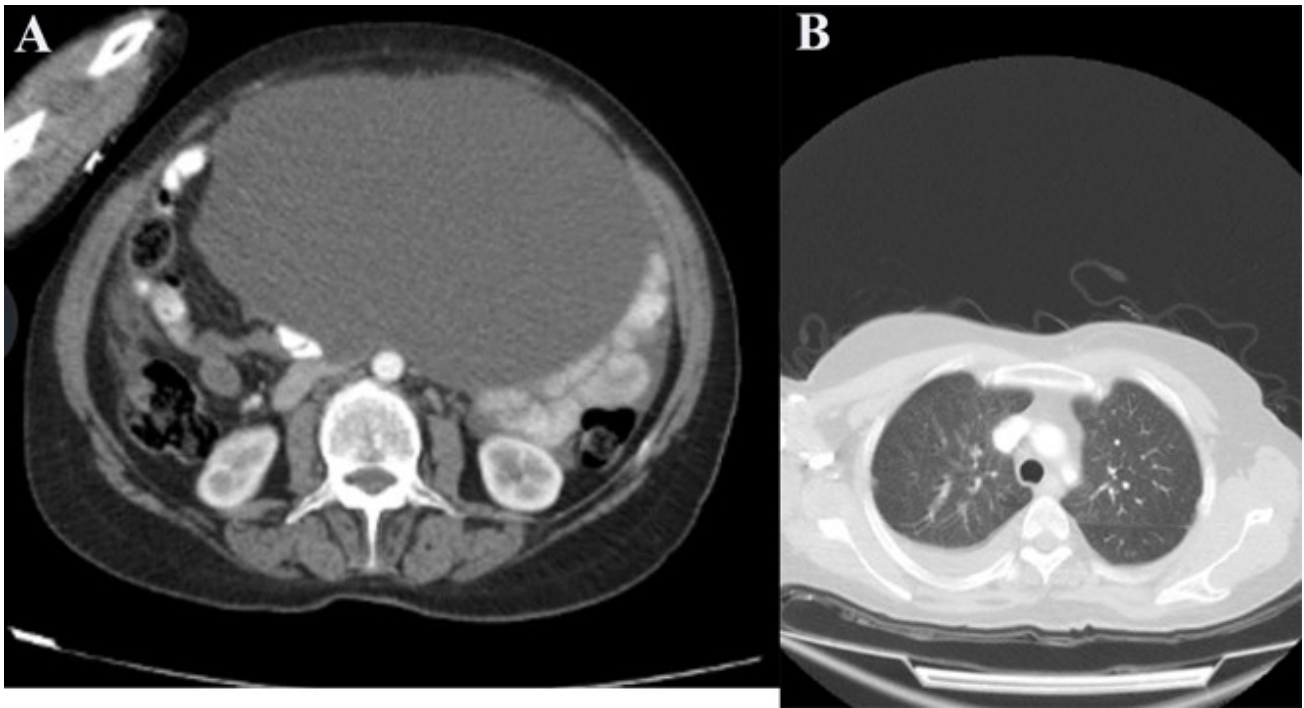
Contrast-enhanced computed tomography findings. (A) Axial abdominal computed tomography (CT) image showing a giant, well-circumscribed heterogeneous abdominopelvic mass displacing adjacent bowel loops, accompanied by intra-abdominal ascites. No definite peritoneal implants or omental caking are clearly visible on the provided image. (B) Axial thoracic CT image showing right-sided pleural effusion with mild adjacent compressive atelectasis; no definite pulmonary nodules, masses, or mediastinal lymphadenopathy are identified on the provided image.
